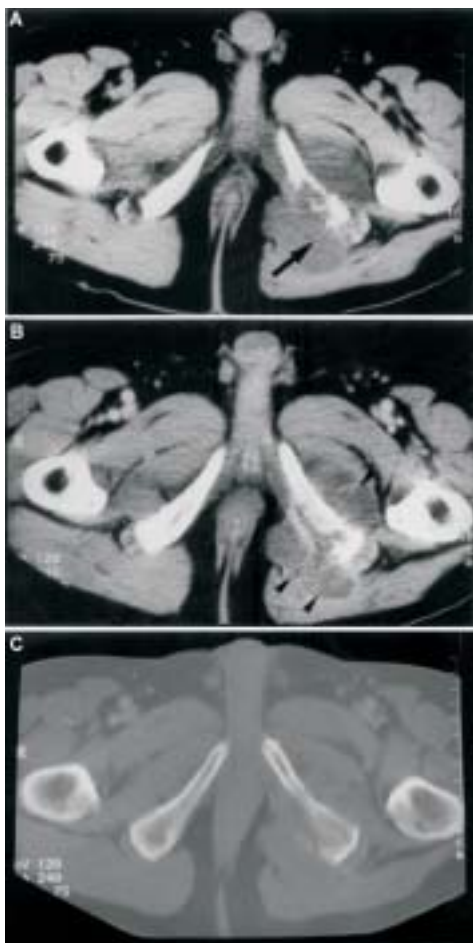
Finding of CT scans of the pelvis. (A) Intramedullary bone destruction at the left ischial bone breaking through the cortex into the adjacent prominent soft tissue mass (arrow) but without calcification or tumor matrix present in the intramedullary cavity. (B) After contrast injection, the soft tissue component is slightly more hypodense than the muscle, with peripheral enhancement and central area of low density representing necrosis or fluid collection (arrowheads). (C) No definite periosteal reaction is apparent in the bone window scans.
